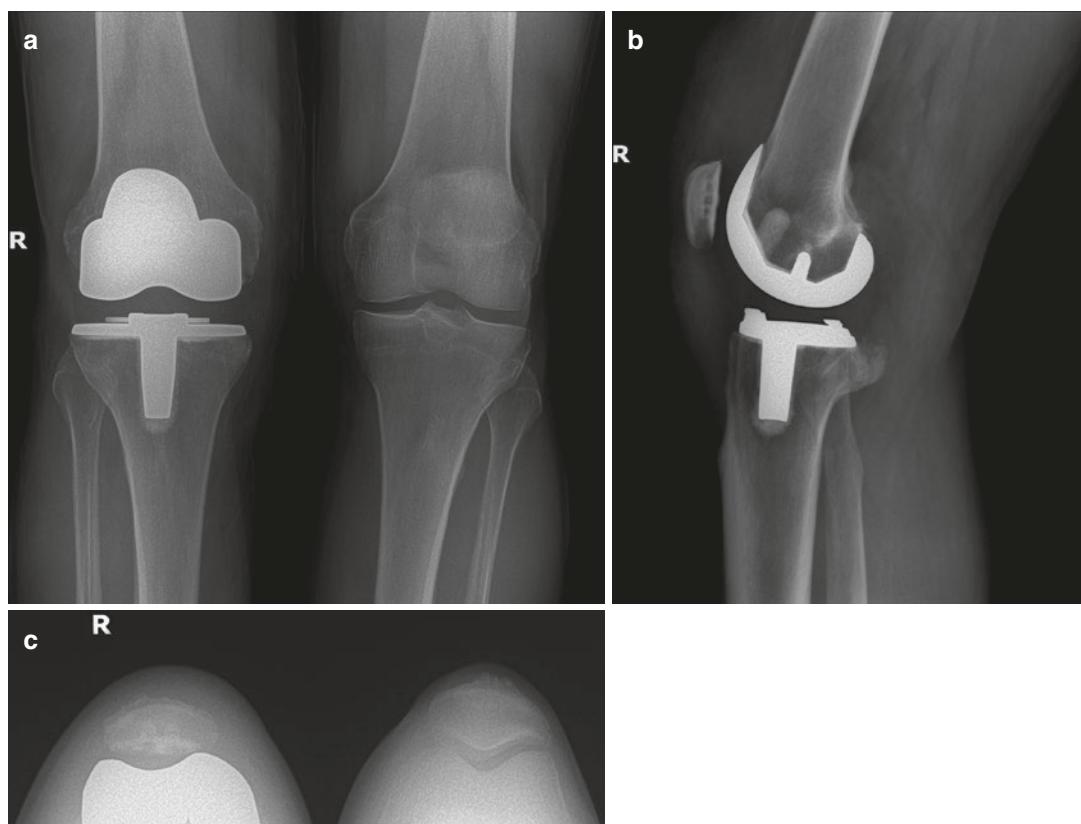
Six-week follow-up. (a) Anteroposterior (AP), (b) lateral, and (c) sunrise radiographs
